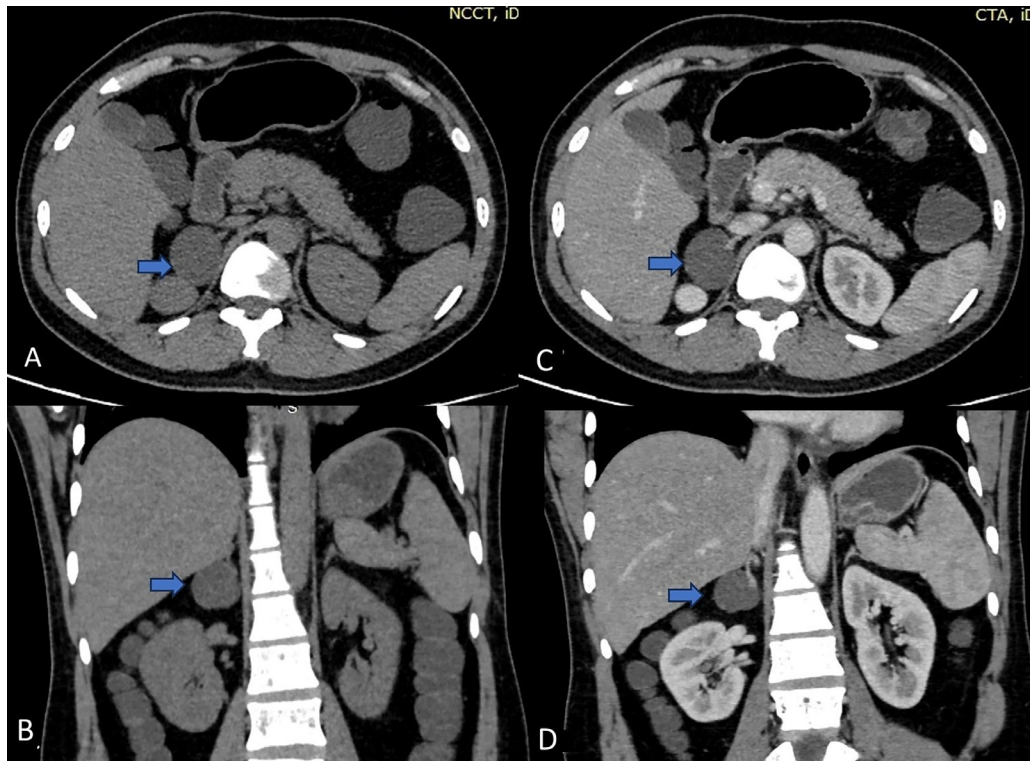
Noncontrast (A) axial, (B) coronal and contrast enhanced (C) axial, (D) coronal computed tomography images through the abdomen showing thin-walled cystic lesion in the right adrenal without enhancement, solid component or enhancing septations. (arrows)
